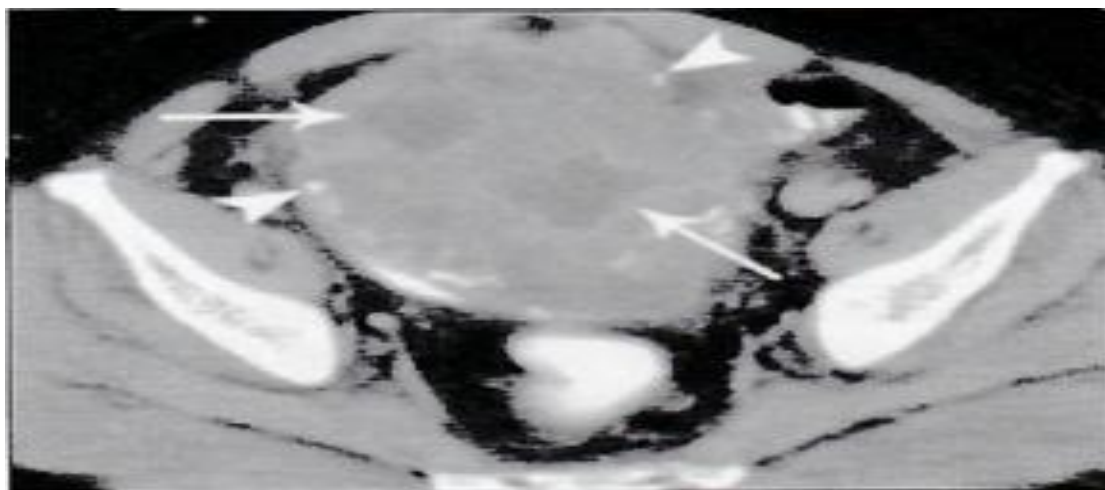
Axial CT image of urinary bladder showing Adenocarcinoma having solid & cystic component with peripheral calcification
